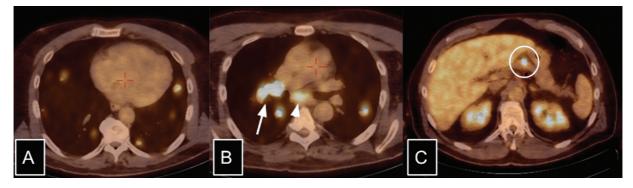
FDG PET-CT: (A) Multiple bilateral hypermetabolic pulmonary nodules with an SUV max of 8.1 noted corresponding to the nodules seen on the preoperative CT chest. (B) Hypermetabolic enlarged right hilar lymph node with an SUV max of 33 (arrow) and enlarged subcarinal lymph node with SUV max of 6.0 (arrowhead). (C) Hypermetabolic focus in the body of pancreas with SUV max of 6.7 (circled) suspicious for metastatic focus.
